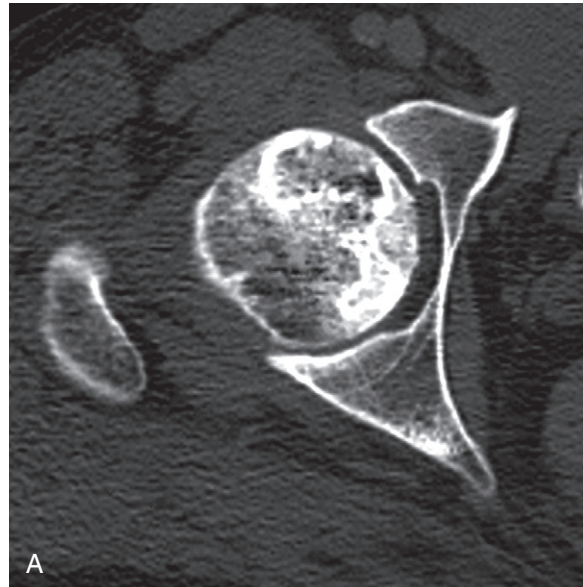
A, Computed tomography scan shows osteonecrosis of the femoral head. Although there are several sclerotic foci within the trabecular bone, the integrity of the osseous structures is preserved and the femoral head exhibits normal spherical shape. B, In more advanced stage of osteonecrosis of the femoral head, note increased sclerosis in the posterior aspect (solid arrow) and subchondral collapse of necrotic bone anterolaterally (open arrow).
